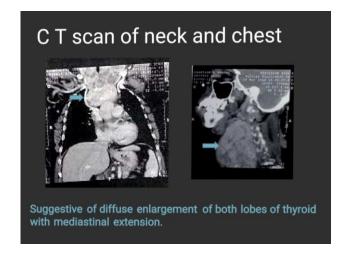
CT scan of neck and thorax showing multinodular goitre with mediastinal extension.
